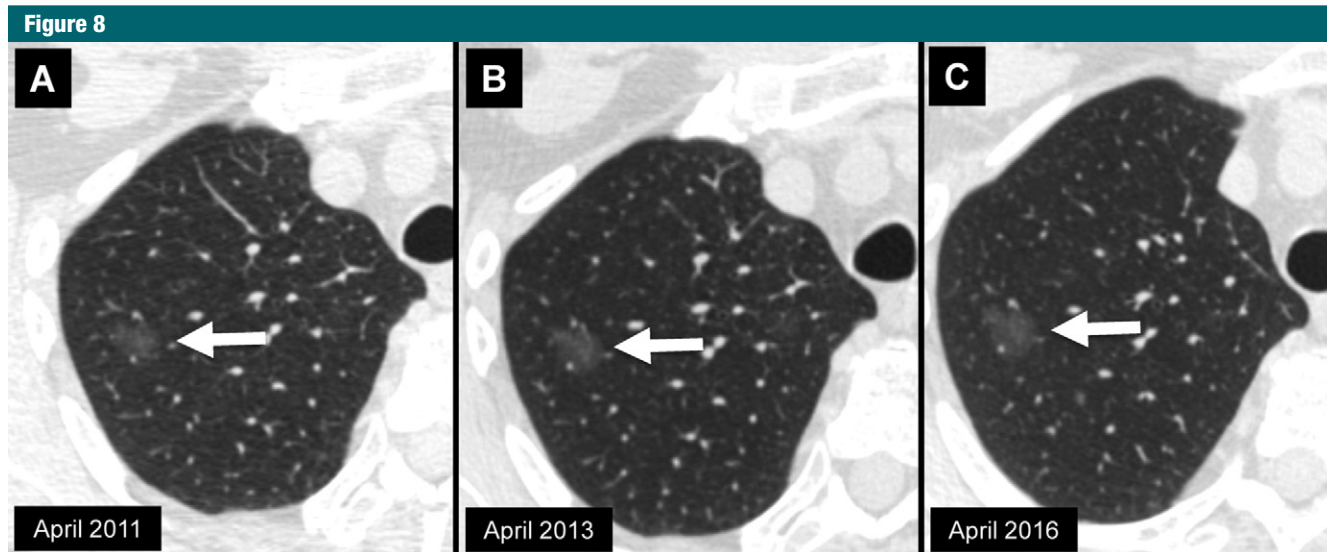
Sequential transverse CT sections through a ground-glass nodule (arrow) in the right upper lobe. Average diameters of the nodule are A, 13, B, 14, and C, 18 mm. Nodule growth is most obvious when we compare the earliest image with the most recent image.
